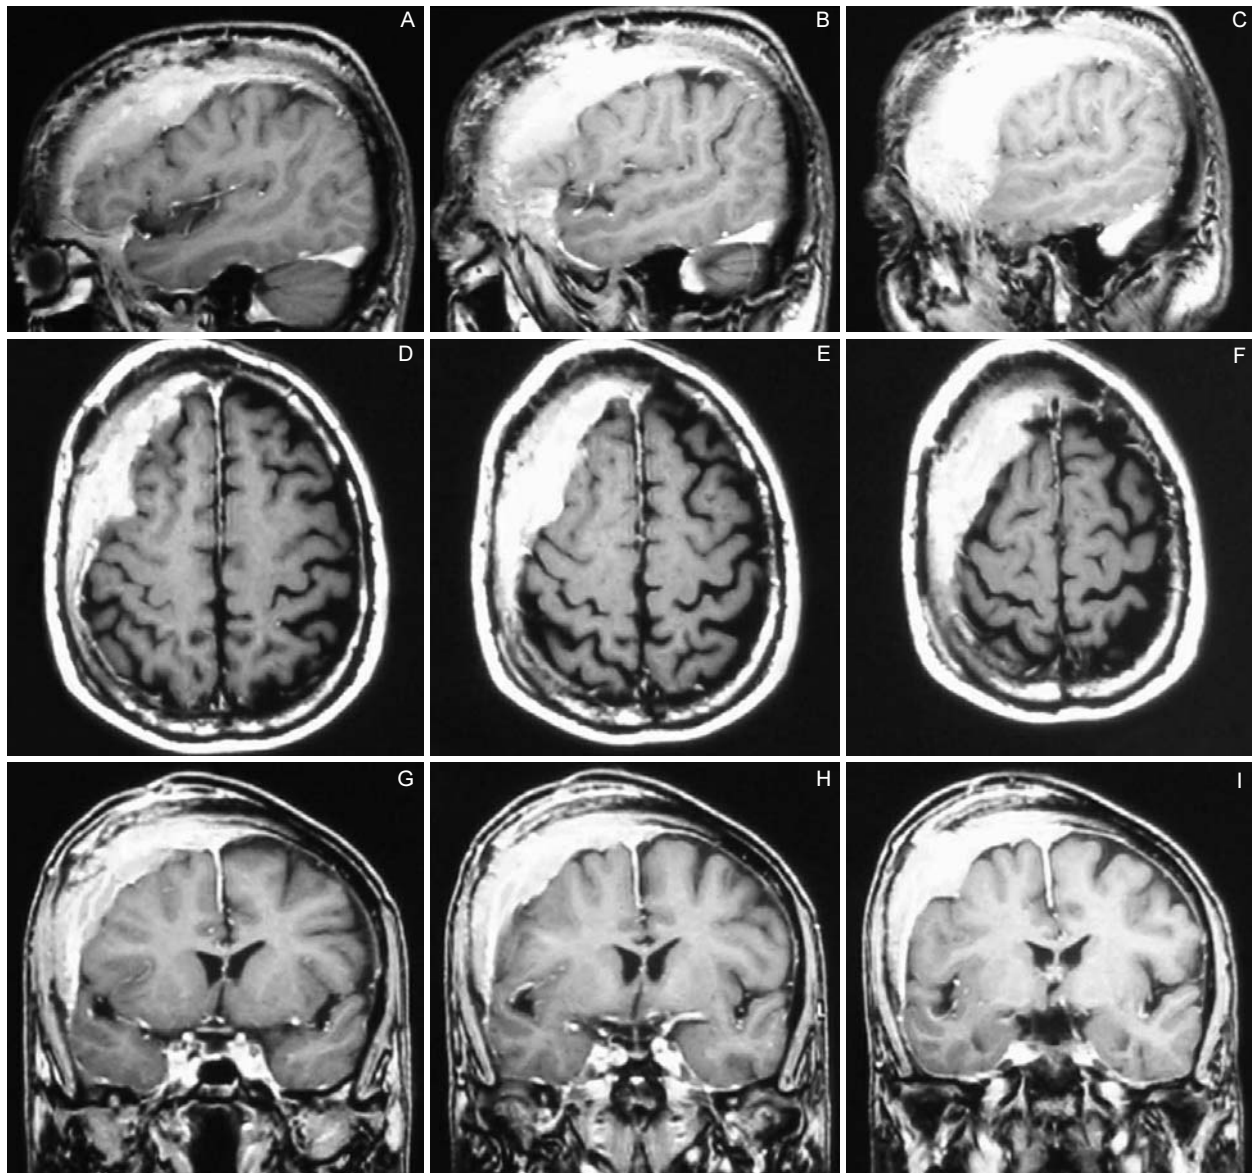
Male, 68 years of age, complains of excessive frontal headaches on a daily basis. Associated with the headaches is swelling of the pericranial soft tissues and tonic-clonic seizures. Coronal (A, B, C), sagittal (D, E, F), and axial (G, H, I), section MRI in T1 with gadolinium. Right fronto-parietal meningioma.
